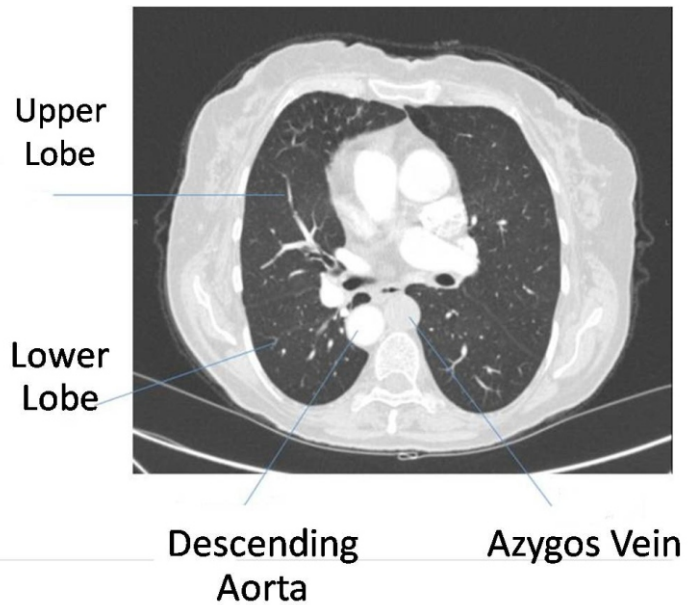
Axial single-slice computed tomography through the chest. Dextrocardia is again demonstrated. The azygos vein is seen on the left side and is prominent. The lungs are bilobed bilaterally and the middle lobe is absent.
